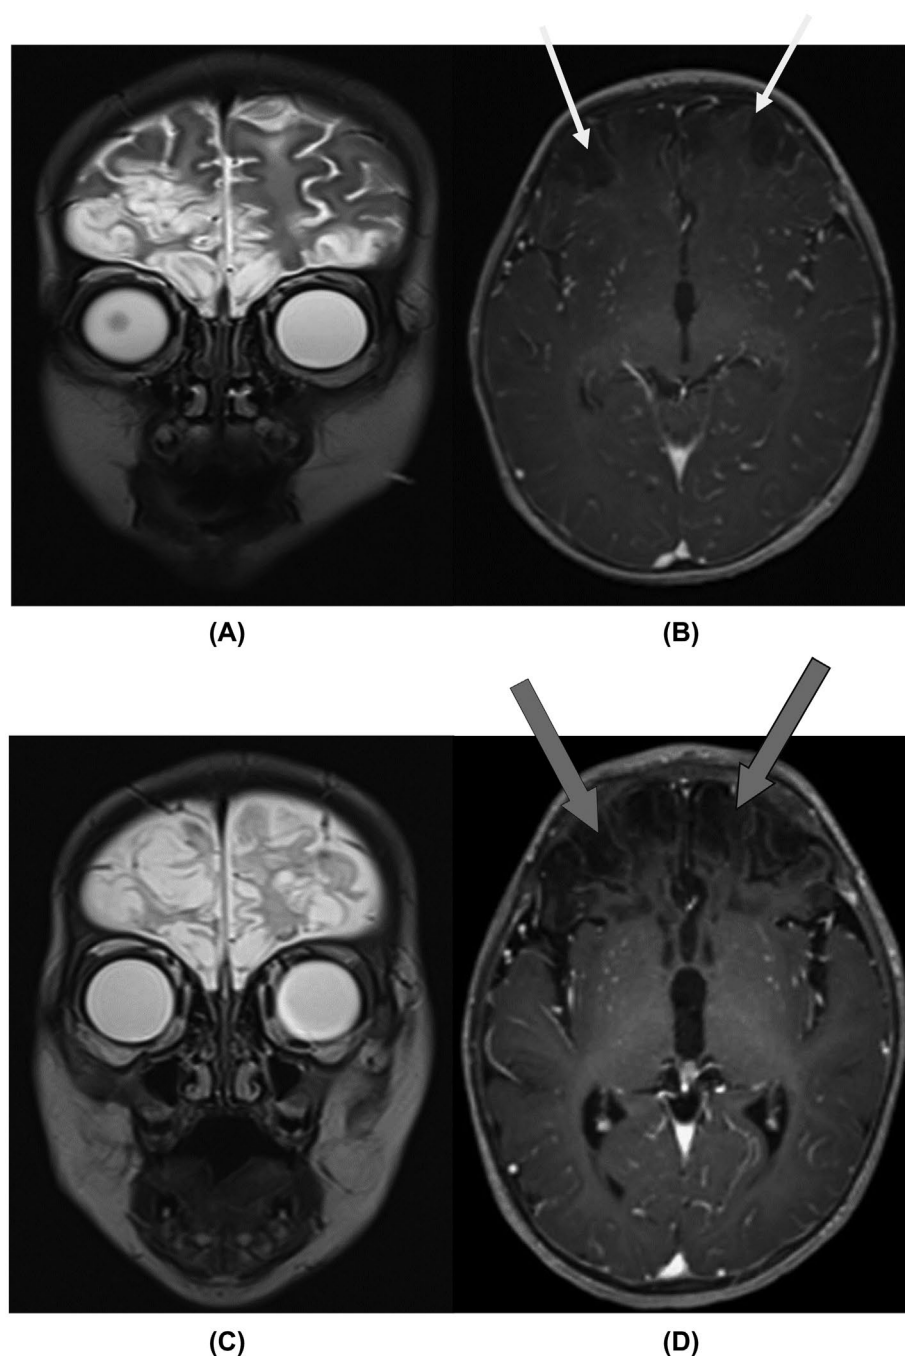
Case 3: Initial MR images (day 3 of admission): (A) T2-weighted SE (3000/120/1) (TR/TE/NEX), and (B) Gadolinium enhanced T1-weighted SE (400/15/2) (TR/TE/NEX) show bilateral asymmetrical cortical and sub-cortical cystic encephalomalacia in the frontal lobes (white arrows). MR after 2 weeks: (C) T2-weighted SE, and (D) Gadolinium-enhanced T1-weighted SE with same parameters demonstrate progressive bilateral frontal cystic encephalomalacia without abnormal enhancement (grey arrows).
